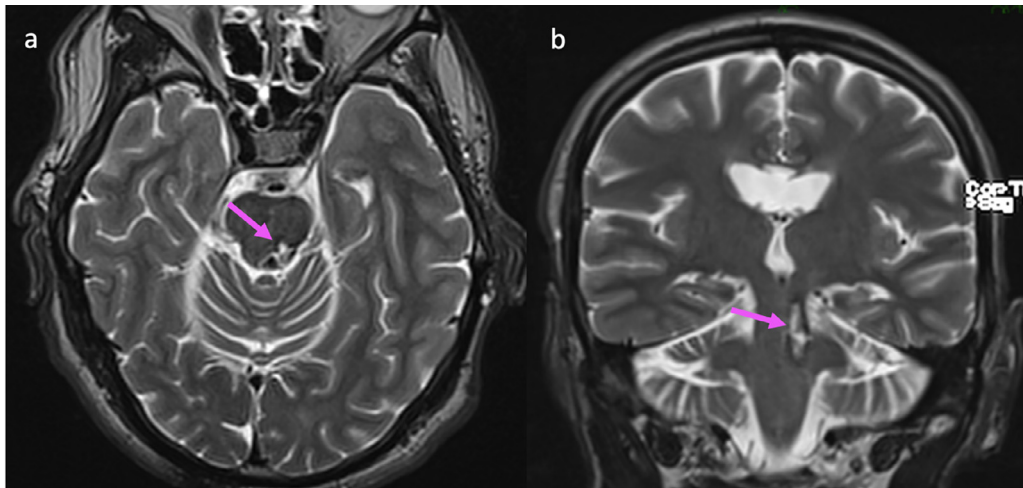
Brain MRI imaging on axial (A) and coronal (B) T2-weighted section which reveals a left tegmental pontine cavernoma extending to the left superior and middle cerebellar peduncles (Pink arrow) that appeared as an oblong T2-high-intensity mass in the dorsal pontomesencephalic part, with surrounding hypointensity which represents hemosiderin and ferritin deposited from an old hemorrhage.
